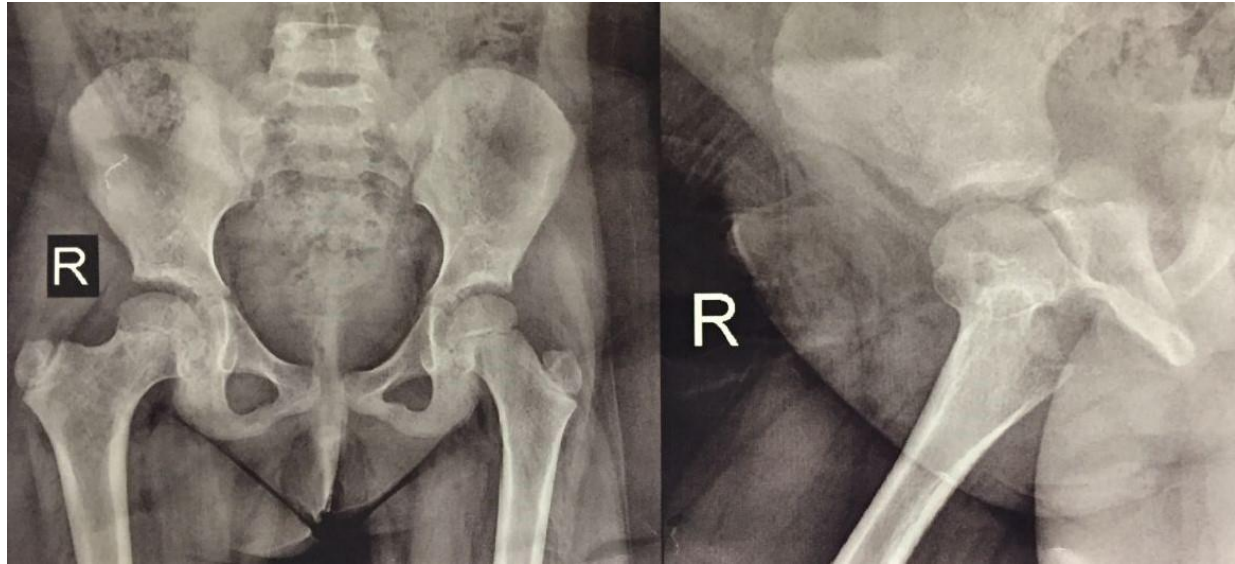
3 year post-op radiograph.
